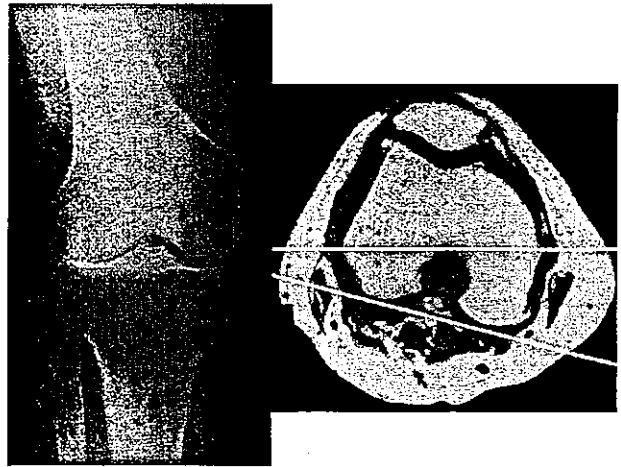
Standing AP radiograph of the valgus knee (Left). Magnetic resonance image of the axial view of the distal femur in the valgus knee (Right). The posterior part of the lateral condyle was relatively small compared to that of the medial condyle, and the transepicondylar axis was externally rotated 11° from the posterior condylar tangent.
